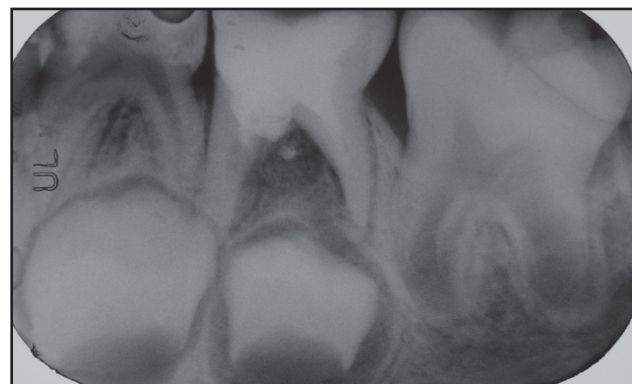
Immediate postoperative radiograph of a tooth with a furcal perforation treated with mineral trioxide aggregate.
